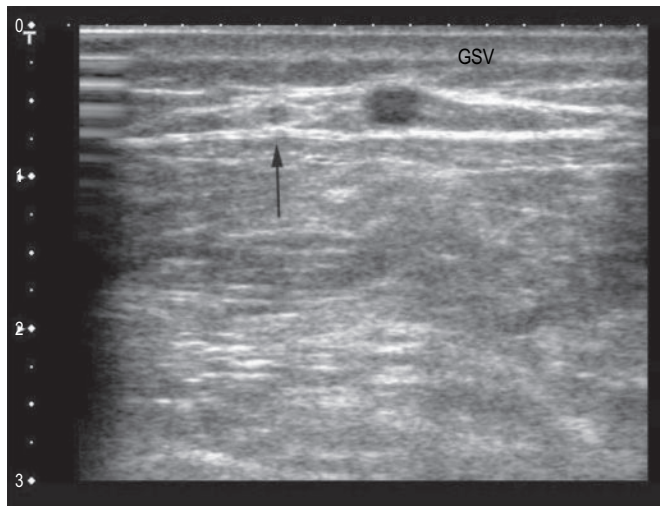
The saphenous nerve, initially in a deeper position, becomes superficial and anterior to the GSV, coming in close contact with the vein ('risk point') at about 2–3 cm below and medial to the tibial tuberosity. The nerve is visible using ultrasound with a high frequency probe (12–18 MHz).
